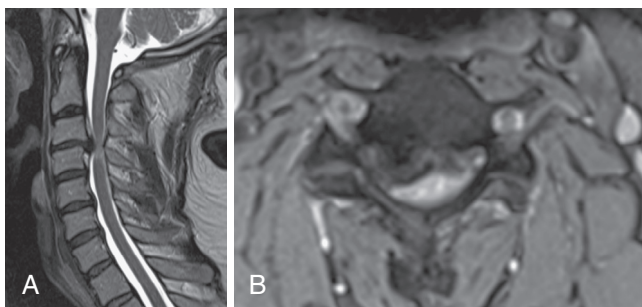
Magnetic resonance images of C3-4 hard cervical disc herniation.
